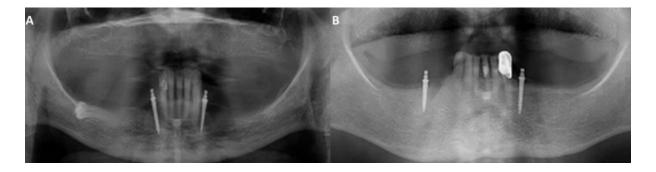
Panoramic radiograph of the patient with impacted third molar (A) and missing abutment teeth in posterior mandible rehabilitated with an MDI to support RPD.
